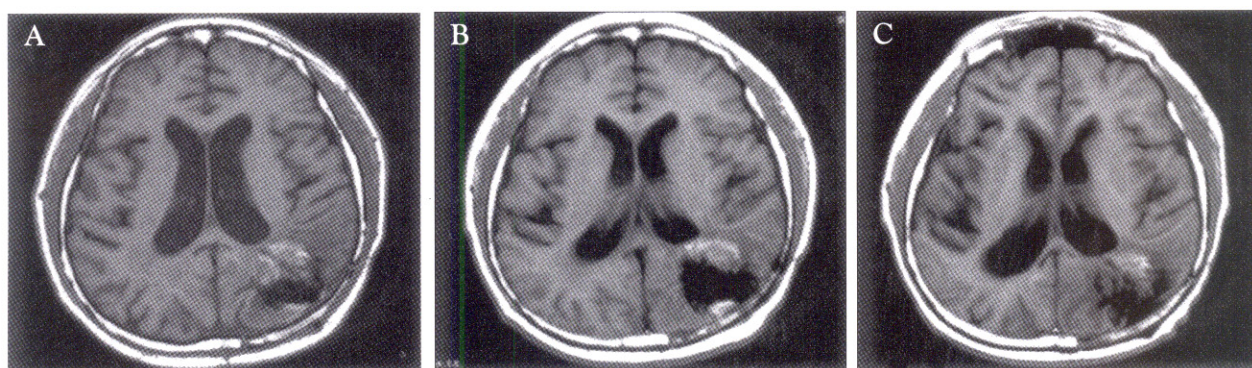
MRI of the brain show enlargement of the tumor size; (A) before and (B) after the emergence of the Leser-Trélat sign. (C) Slightly decreased tumor size 4 months after the 2 additional temozolomide chemotherapy treatments.
